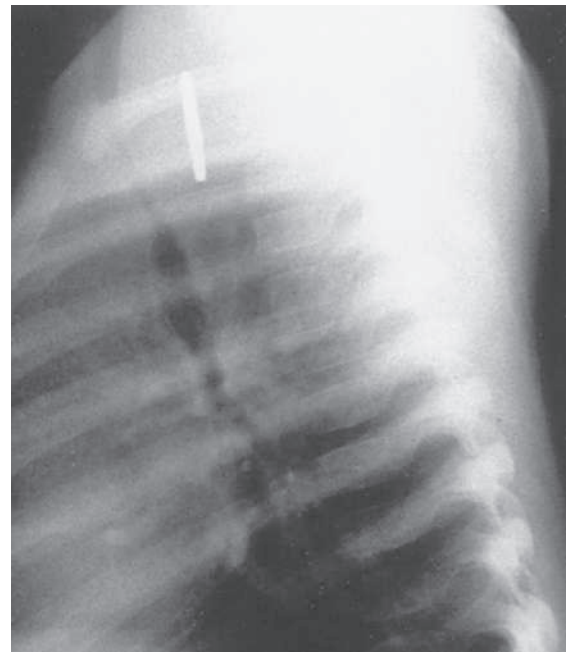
Foreign body is noted in the bronchus on a chest radiograph.
